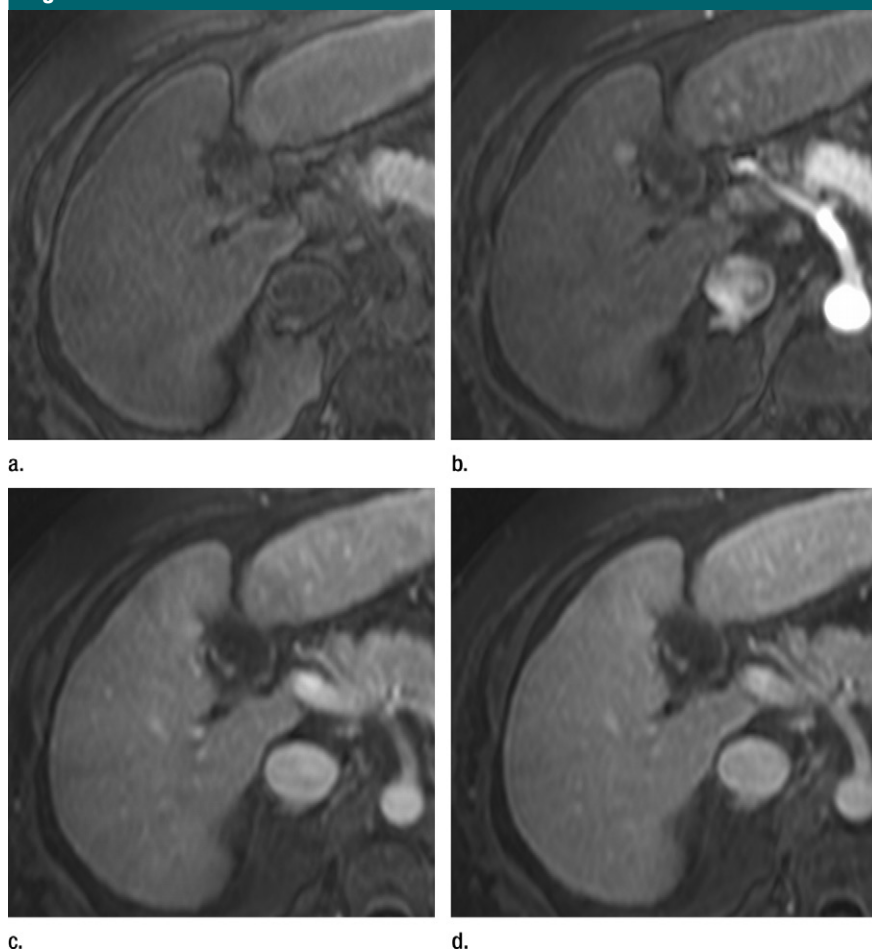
(a–d) Axial fat-suppressed T1-weighted volumetric interpolated breath-hold examination (VIBE) MR images of the liver obtained in 50-year-old woman with alcoholic cirrhosis (a) before and (b–d) after contrast agent administration in the (b) arterial, (c) portal venous, and (d) delayed phases. There is a 10-mm nodule in segment V adjacent to the gallbladder that is slightly hyperintense on a and shows arterial phase hyperenhancement on b without washout or pseudocapsule on c and d. A LI-RADS category of 3 was assigned. This nodule corresponds to a regenerative nodule that has remained stable for 83 months as of this writing.
